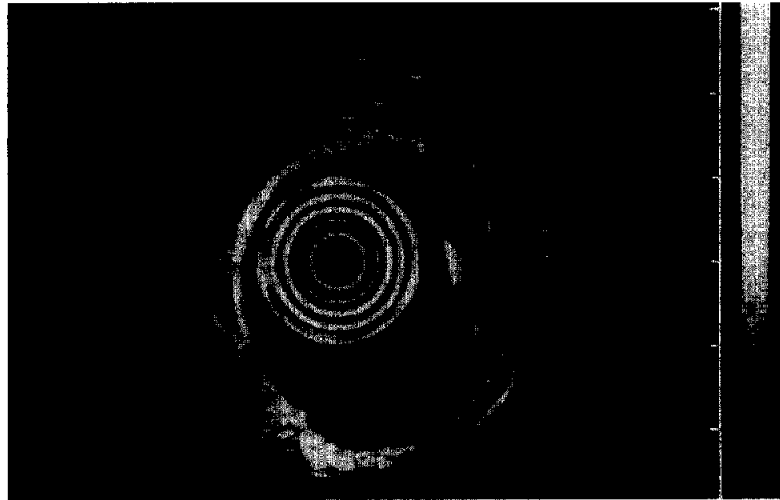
Endoscopic ultrasonography revealed a submucosal tumor of the gastroesophageal junction in this patient, whose presentation was otherwise suggestive of primary achalasia. The tumor is seen as a large echolucent area extending from the 4-o'clock to 6-o'clock position. The lesion was not seen on several prior endoscopic examinations.
